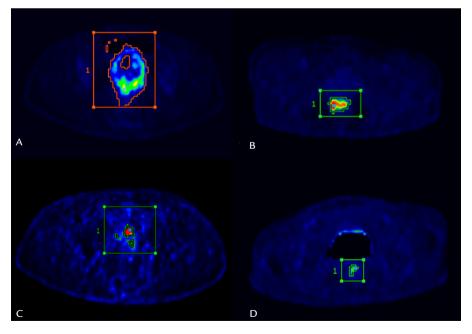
Typical example of ¹⁸F-FDG PET/CT image tumor segmentation using 2SD individualized algorithm. A. Tumor segmentation pre-therapy in non-responder. B. Tumor segmentation post-therapy in non-responder. C. Tumor segmentation pre-therapy in responder. D. Tumor segmentation post-therapy in responder.
